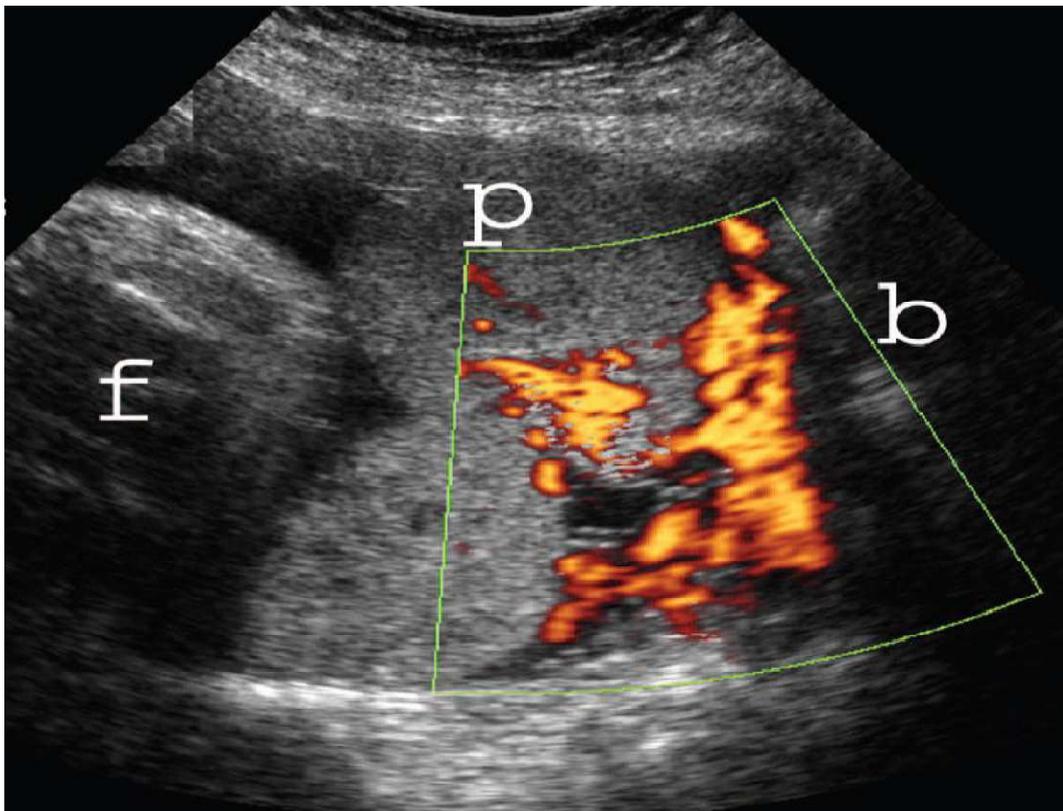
Color Doppler of placenta percreta. Note the vascularity of the bladder wall (b). At surgery, the bladder wall was involved. p, placenta; f, fetus.<sup>(14)</sup>
